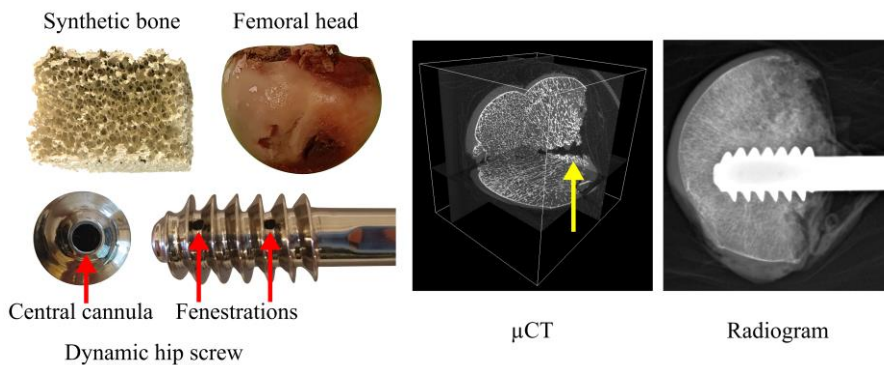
Samples and images acquired for study V. From left to right: Synthetic bone block; femoral head; Dynamic hip screws (cannulated and fenestrated); μ CT scan of a femoral head (the arrow indicates the hole left by the extractor screw); Radiographic image of a femoral head after screw insertion.
